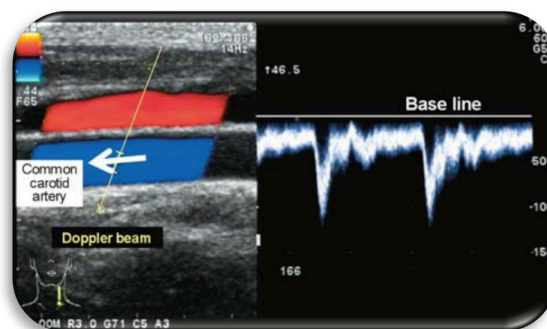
Pulse Doppler Method
